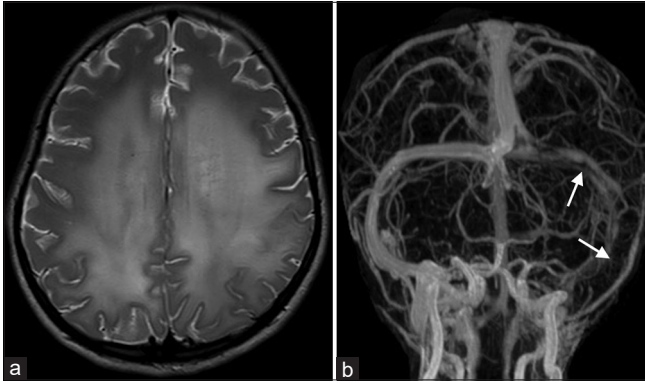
Last MRI brain performed due to further neurological deterioration shows: (a) Increase in the white matter involvement with abnormal frontal white matter. (b) Left side transverse, sigmoid, and jugular venous thrombosis (arrows).
